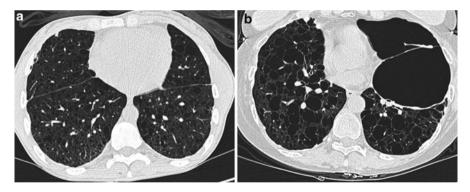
Characteristic moderate and severe LAM CT. Numerous thin-walled cysts that are widely distributed are characteristic of LAM as seen in the CT images from LAM patients with moderate (a) and severe (b) disease
